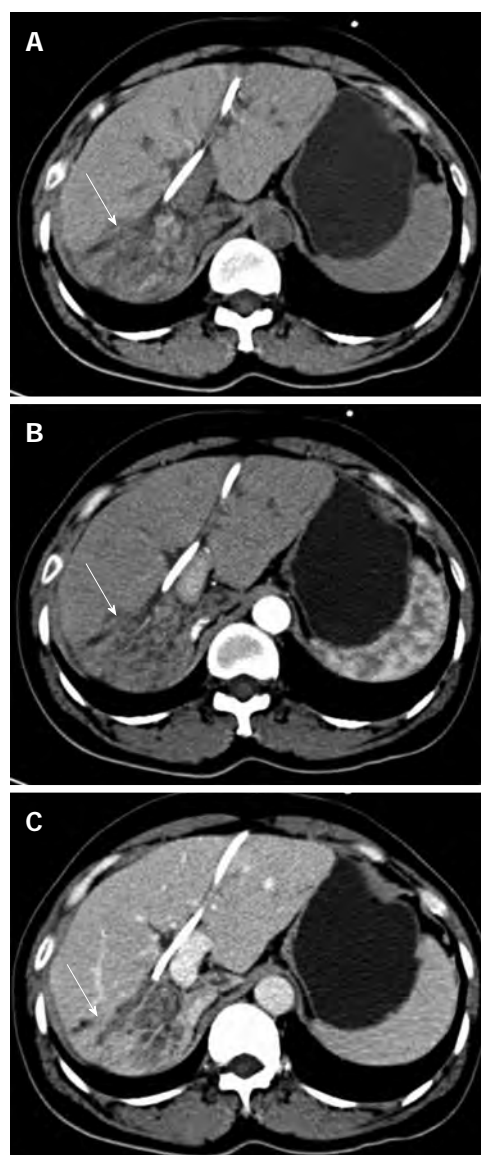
Preoperative computed tomography scan shows hepatolithiasis in the right liver with hepatic parenchymal atrophy (arrow). A: Non-contrast; B: Arterial phase; C: Venous phase.
